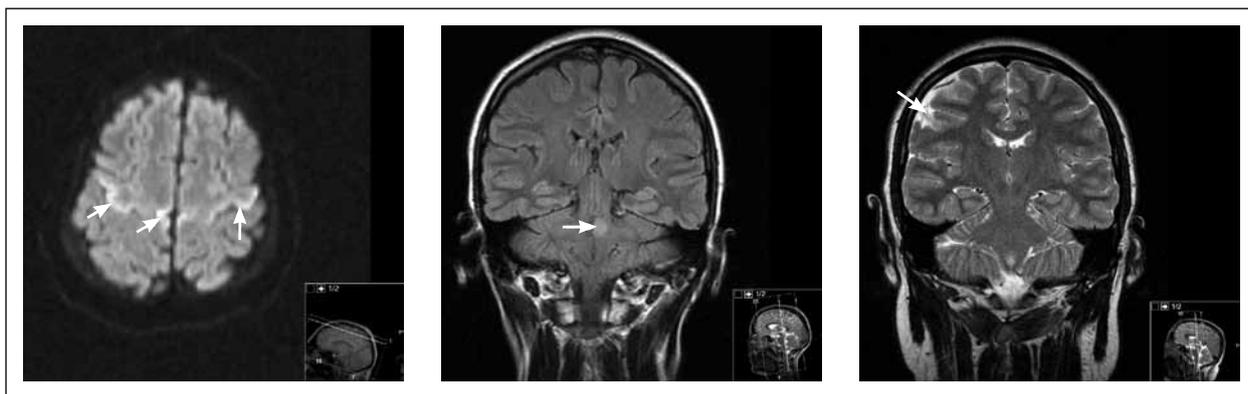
C (A) Missed hypoxic ischaemic change bilaterally demonstrated on axial diffusion weighted imaging magnetic resonance imaging (MRI) scan of brain (arrows). (B) Demyelination in left pons – misinterpreted as possible glioma on coronal T2-FLAIR image (arrow). (C) Missed destructive right cortical lesion demonstrated on coronal T2 MRI scan (arrow).
